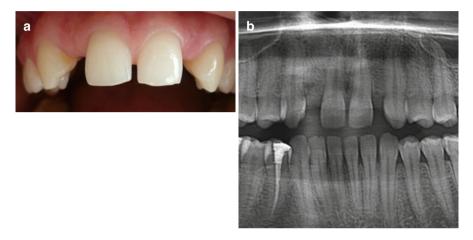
(a) Clinical and (b) radiographic appearance of a generalized diastema in a case with bilateral congenitally missing maxillary lateral incisors
